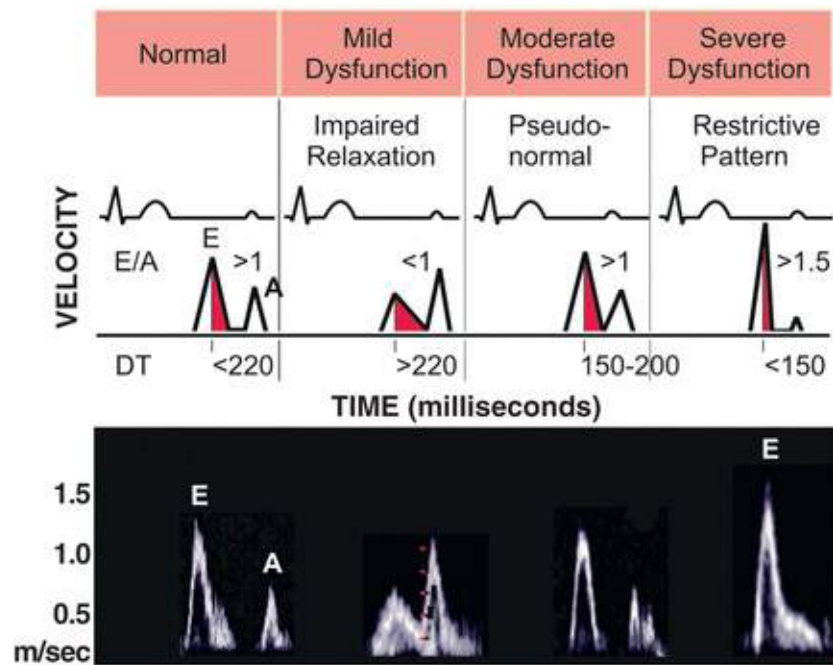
Mitral inflow Doppler waveforms in diastolic dysfunction. *DT*, Deceleration time. (Modified from Ho CY, Bulwer BE. Echocardiographic assessment of diastolic function. In Solomon SD, Bulwer BE, editors. Essential Echocardiography. A Practical Handbook with DVD. Totowa, NJ: Humana Press; 2007, p 124.)
